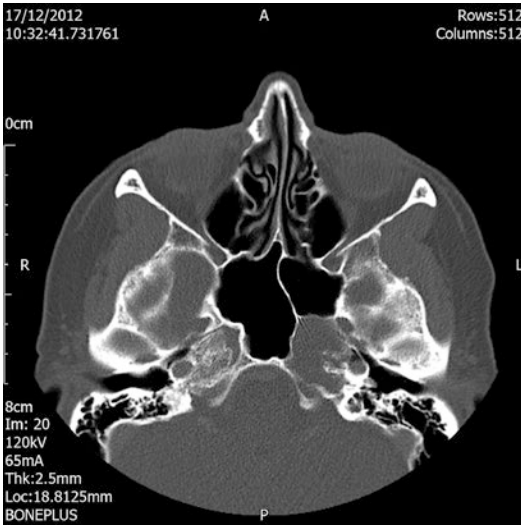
Axial CT with contrast revealing a destructive lesion involving the left petrous apex
